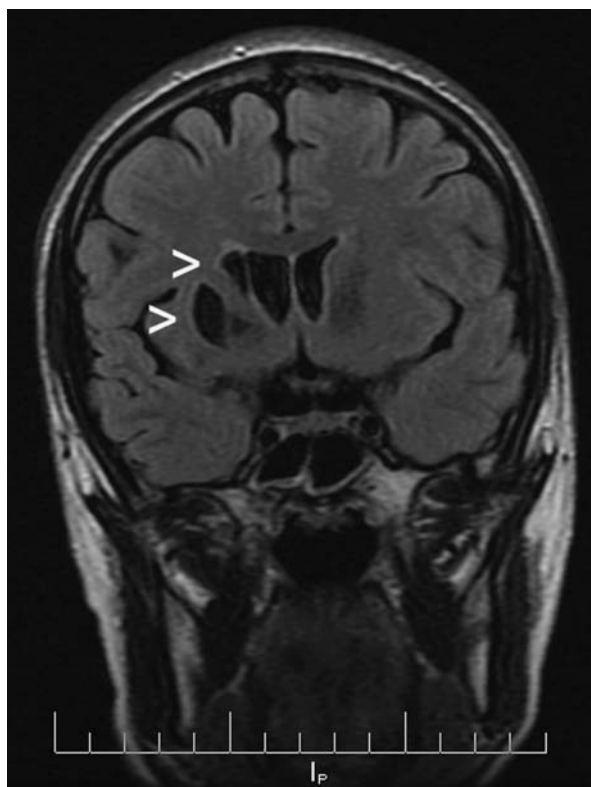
Magnetic resonance image confirming chronic ischemic lesions of the caudate and lentiform nuclei in the right hemisphere (arrowheads).
